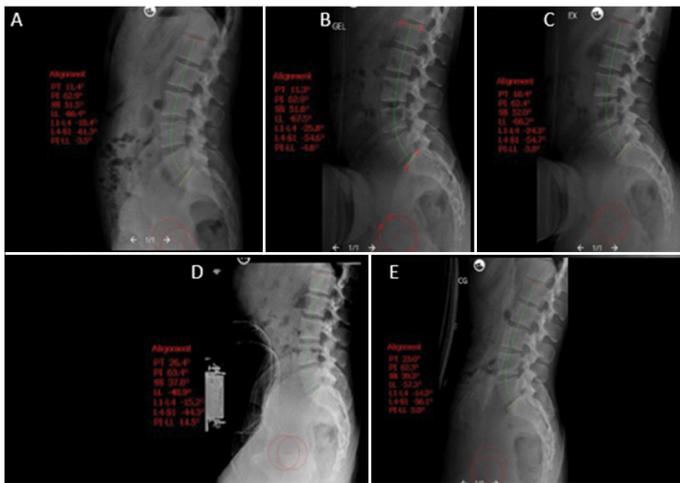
Radiographs in orthostasis (A), gel cushion positioners (B), gel cushion positioners with hip extension (C), Relton-Hall (D) and Wilson (E) positioners.
